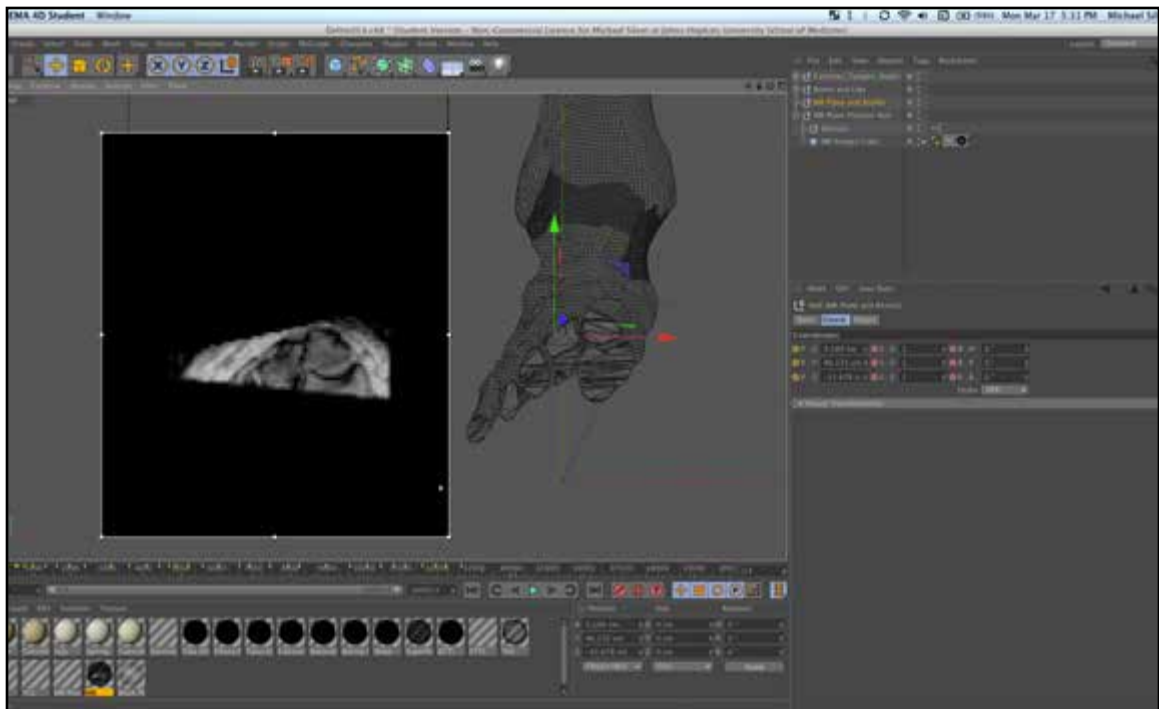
Locating first identifiable MR image and correlated model section location.
